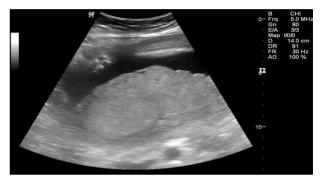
2D ultrasound showing posterior placenta grade II and clear amniotic fluid with absence of free floating particles.
